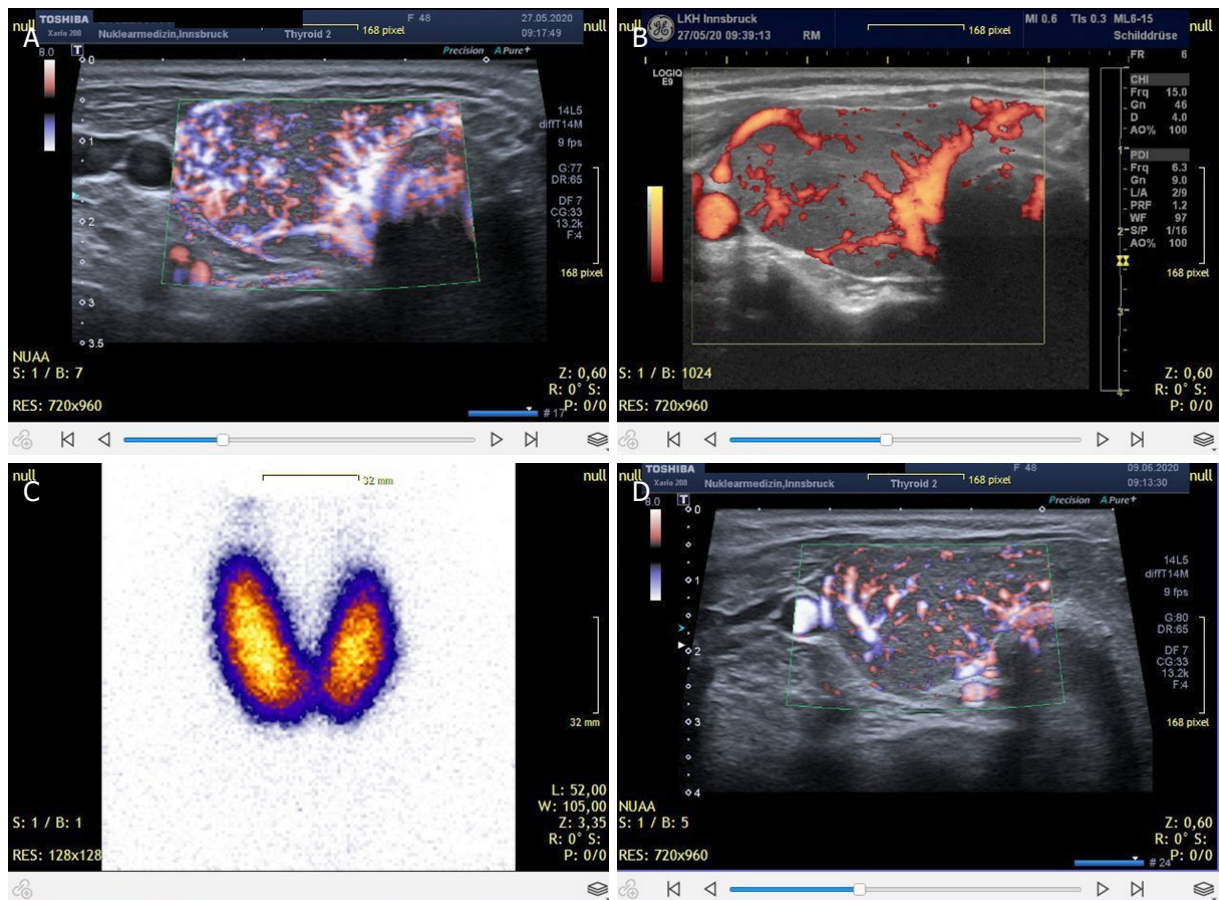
Recently diagnosed case of hyperthyroidism showing hyperperfusion corresponding to CoQ₁₀ deficiency. Sonography images are compared for 2 different machines, i.e., Toshiba (now Canon) (A, B) and Logiq Q9, G.E (C, D). The scintigraphy shows an intense tracer uptake. The lower right panel shows the response to 3 weeks of combined supplementation
